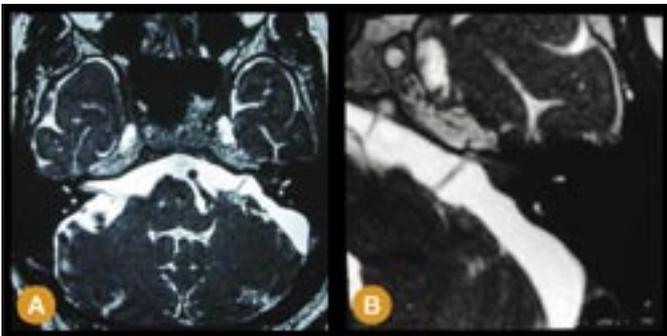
(A) T1-weighted MRI with addition of gadolinium : homogeneous enhancement of a lesion at the left cerebellopontine angle, (B) T2-weighted images.
